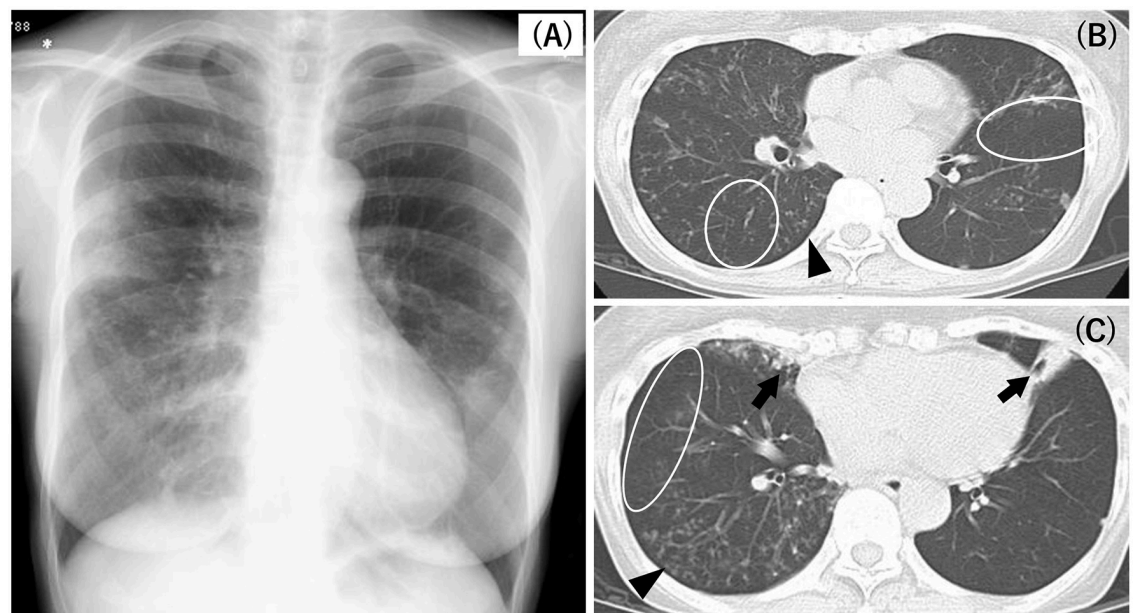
A typical case of low attenuation in MABC-PD. Chest radiograph (A) demonstrates bilateral diaphragm flattening and hyperinflation. Chest HRCT scans (B, C) reveal low-density areas in the lung parenchyma (oval enclosure mark); multi-lobe involvement with consolidation, bronchiectasis, and GGO (arrow) in the right middle lobe and LLS; and a tree-in-bud appearance and small centrilobular nodules in the RLL (arrowhead).
